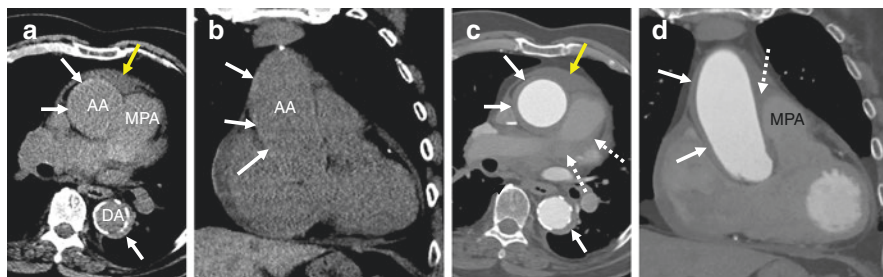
Noncontrast (a, b) and postcontrast (c, d) axial (a, c) and coronal (b, d) CT images demonstrate a type A IMH in a 76-year old man with chest pain. Noncontrast images show a subtle, thin high-density crescent of IMH (white arrows) that is even evident in the posterolateral descending aorta (DA) (a, c). Additional findings of hemopericardium (yellow arrow) and blood in the mediastinum around the main pulmonary artery (MPA) (dotted arrows) are consistent with rupture. AA Ascending aorta
